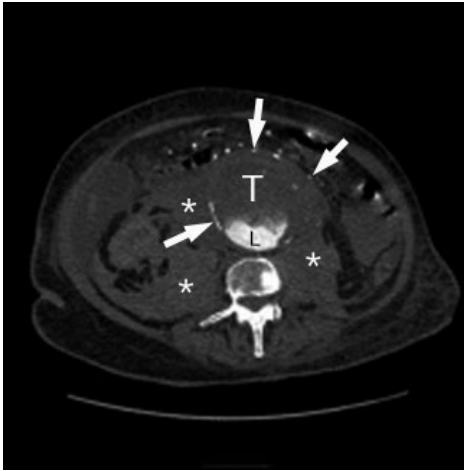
A ruptured abdominal aortic aneurysm on CT. The arrows indicate calcifications in the wall of the vessel, with adjacent retroperitoneal haematoma (*). Between the lumen filled with contrast (L) and the vessel wall is organized thrombus (T). Image courtesy of Maja Jafari.
